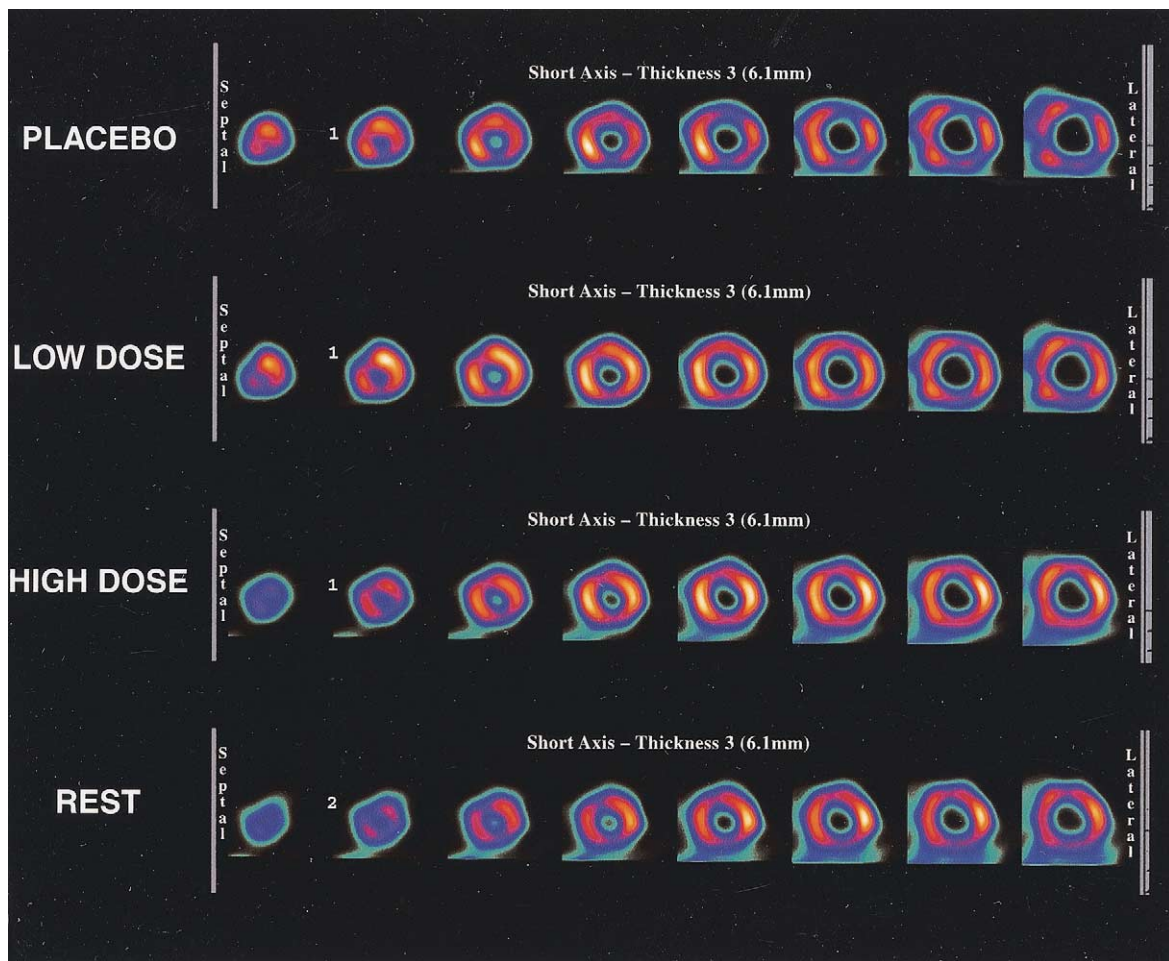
Multiple short-axis slices during dipyridamole Tc-99m sestamibi single-photon emission computed tomography (SPECT) imaging in a patient with coronary artery disease after administration of placebo, low-dose metoprolol, and high-dose metoprolol, as well as Tc-99m sestamibi SPECT imaging at rest. Multiple perfusion abnormalities are present with placebo with marked reduction in size and severity with both doses of metoprolol.
